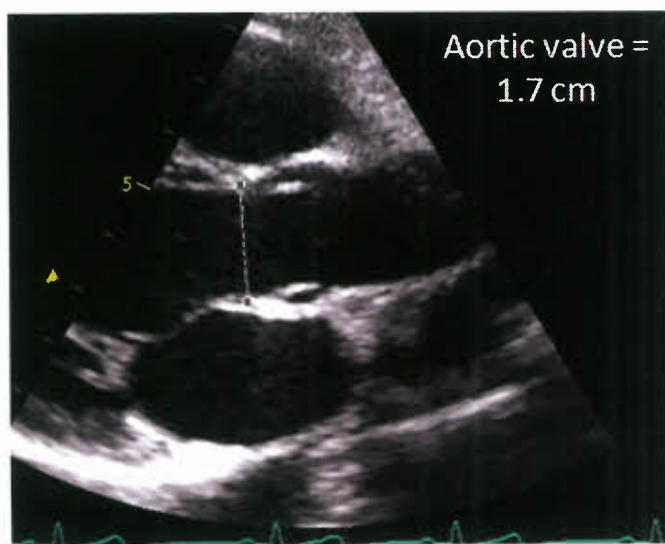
Measurement of the aortic valve annulus. A zoomed parasternal long-axis view of the aortic valve is used. The measurement is performed in early systole. The measurement is made at the aortic valve hinge points.
